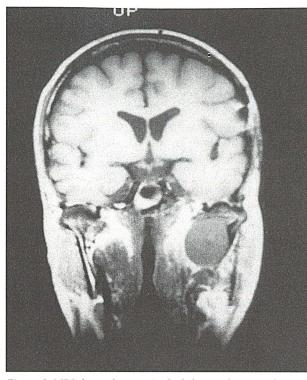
MRI shows the mass in the left parapharyngeal space.
